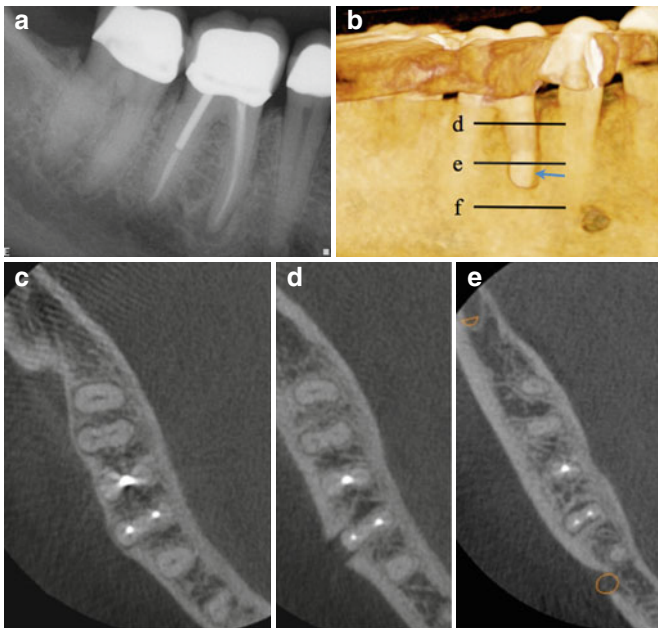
(a) Periapical radiograph of tooth number 30. (b) 3D reconstruction demonstrating the mid-root buccal defect (arrow). Lines correspond to the axial section views (c), (d), and (e). Note axial view demonstrating the mid-root buccal bone loss in (d)
